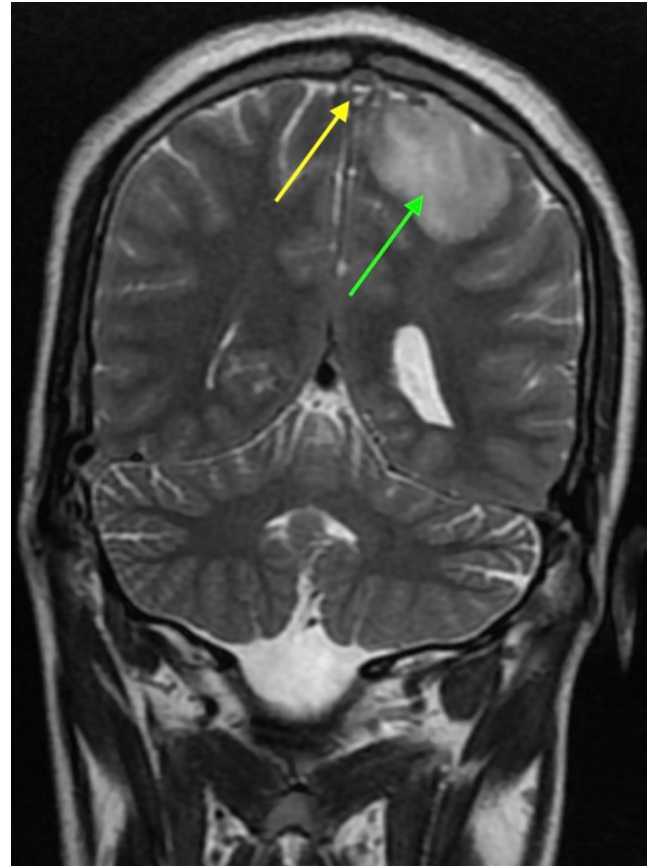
MRI showing superior sagittal sinus thrombosis as evidenced by the hyperintensity shown by the yellow arrow; hemorrhagic transformation (shown by the green arrow).
